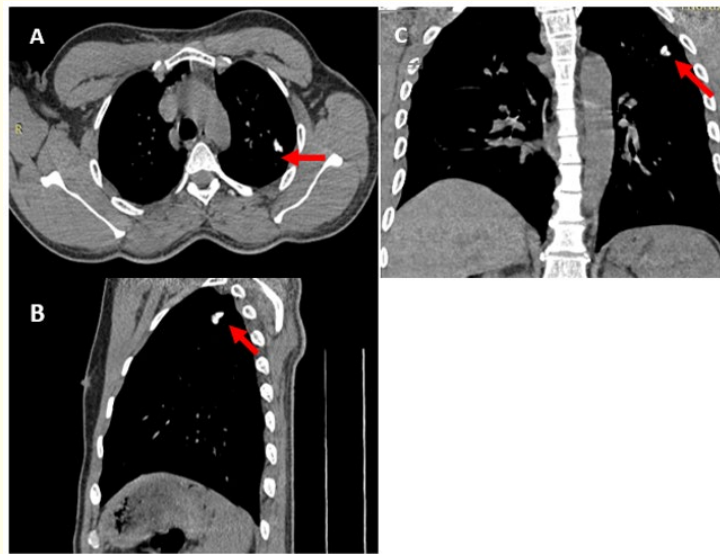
Chest CT images in mediastinal window in axial (A), sagittal (B), and coronal (C) planes showing endobronchial calcification at the level of the apicodorsal segmental bronchus consistent with broncholithiasis (indicated by the arrow).
